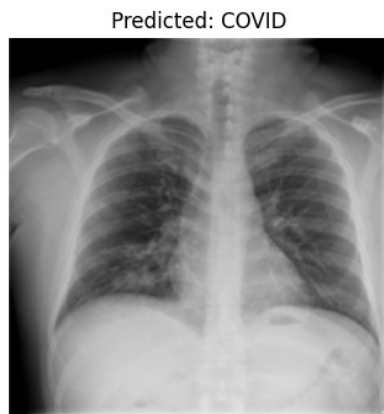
Predicted sample X-ray Image.
